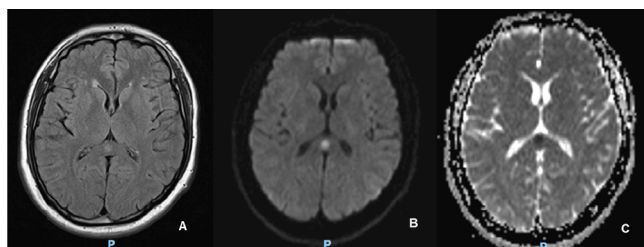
Magnetic resonance imaging demonstrating an ovoid lesion in the splenium of the corpus callosum with fluid-attenuated inversion recovery hyperintensity (A) and restricted diffusion (B, C).
